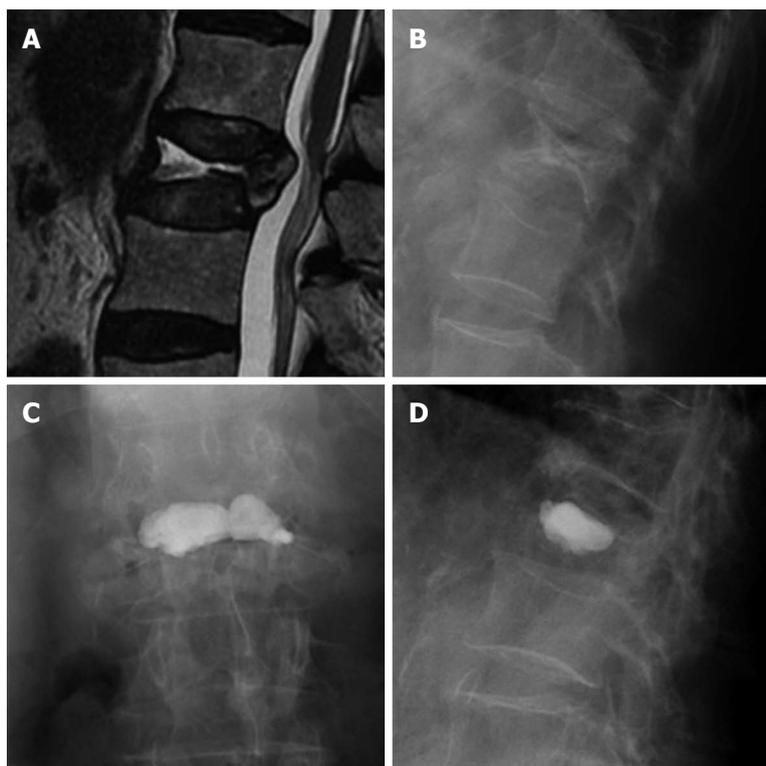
Sagittal T2 weighted image (A) and lateral X-ray film (B) of a vertebral fracture with intravertebral cleft, AP (C) and lateral (D) view after vertebroplasty.
